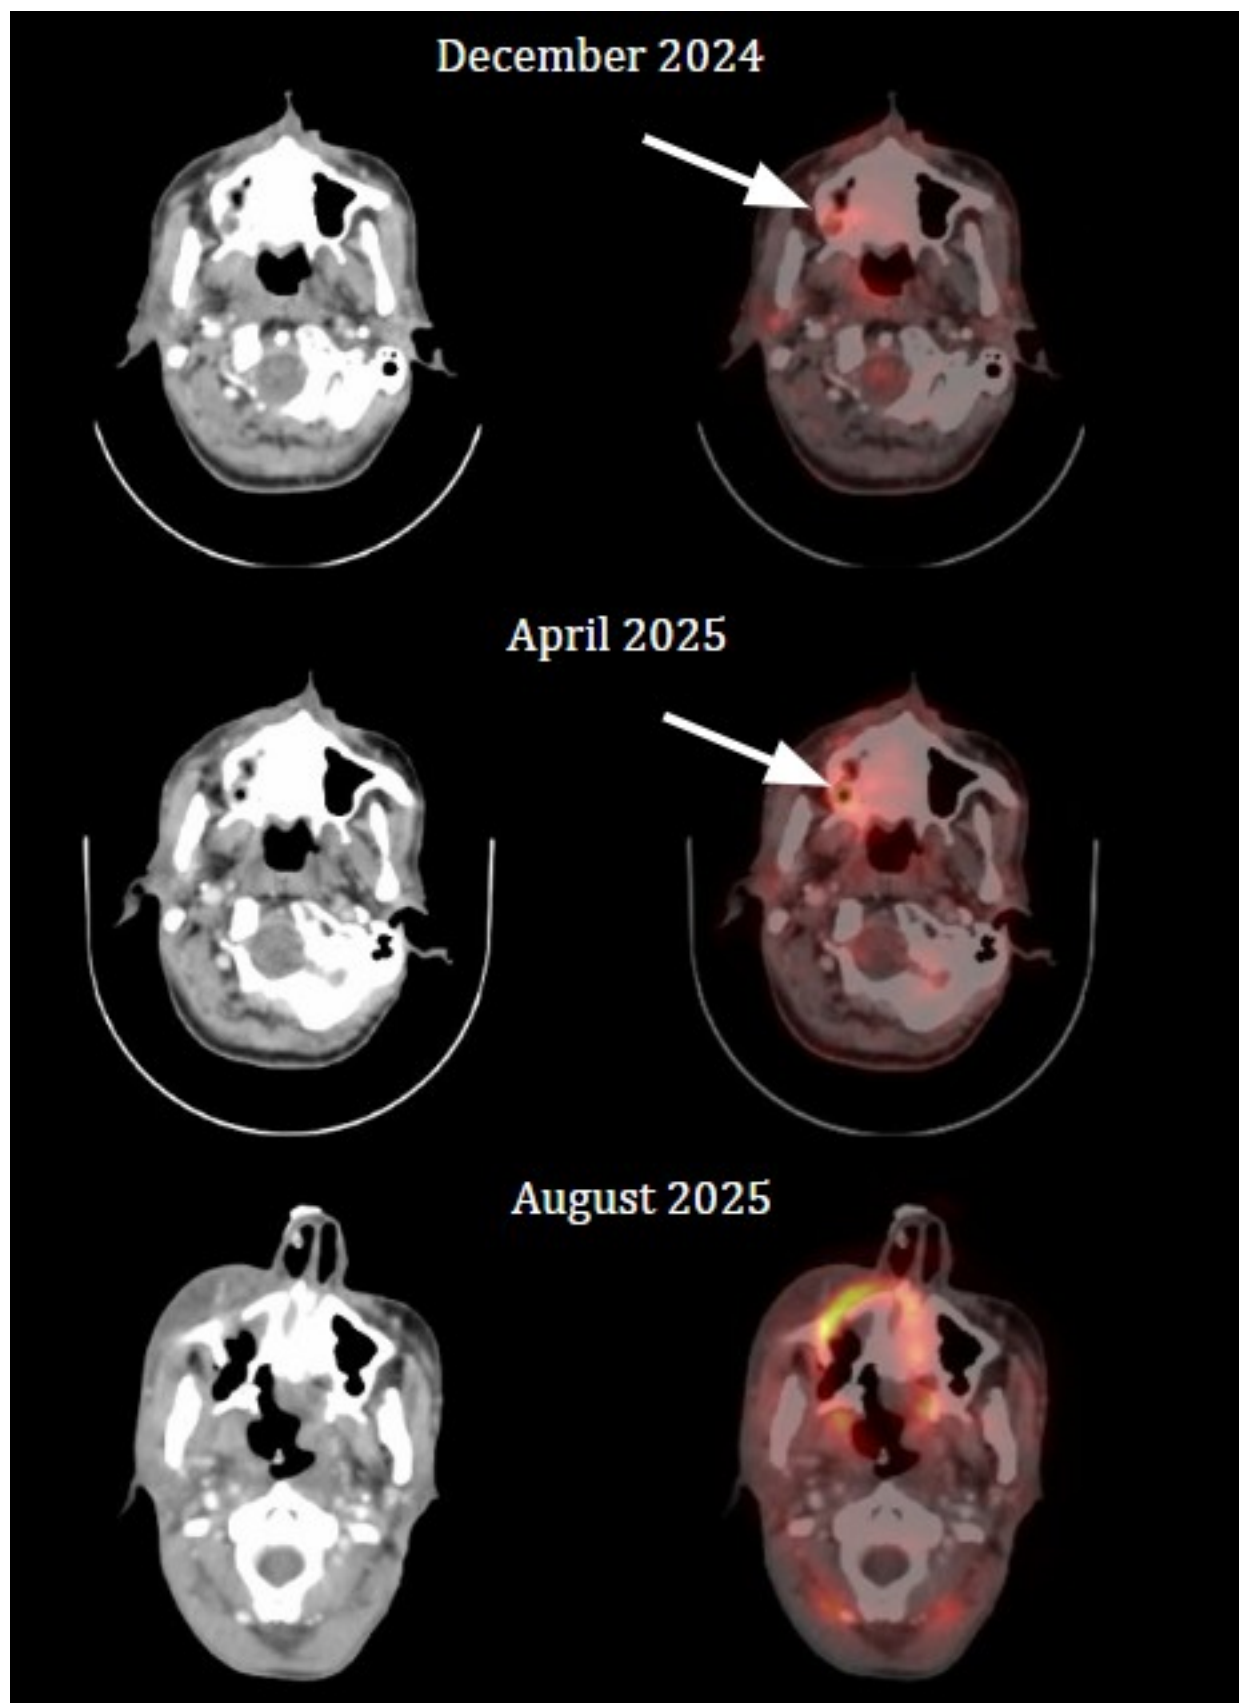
Axial CT and fused PET/CT images corresponding to Figure 2.1. Subtle focal FDG uptake (arrow) is seen along the inferior wall of the right maxillary sinus, appearing indeterminate in December 2024 and reported as negative in April 2025. Clear progression is seen in August 2025.
